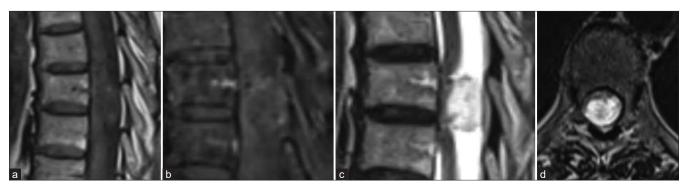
Posterior compressive intradural extramedullary mass at T7, (a) slightly hypointense in T1-weighted sequences, (b) with a discrete annular peripheric enhancement in T1 injected fat saturation (FAT SAT) sequences, (c and d) and hyperintense in T2-weighted sequences.
